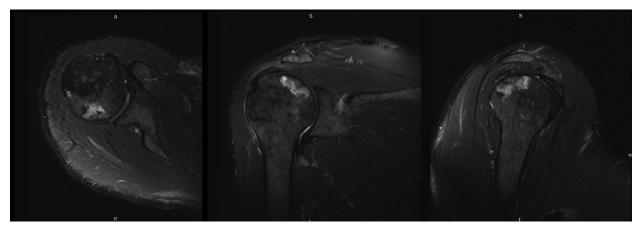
Axial, sagittal and coronal images from a T2 weighted magnetic resonance imaging scan of the right shoulder demonstrate an area of osteonecrosis without humeral head collapse.
